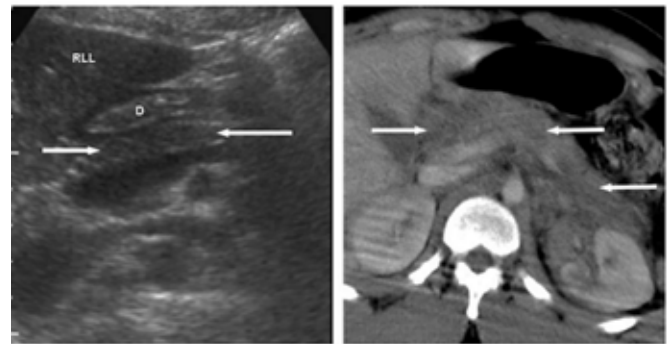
Pancreatic trauma in adults. Image "a" is from an ultrasound, image "b" is from a computed tomography<sup>2</sup>.
